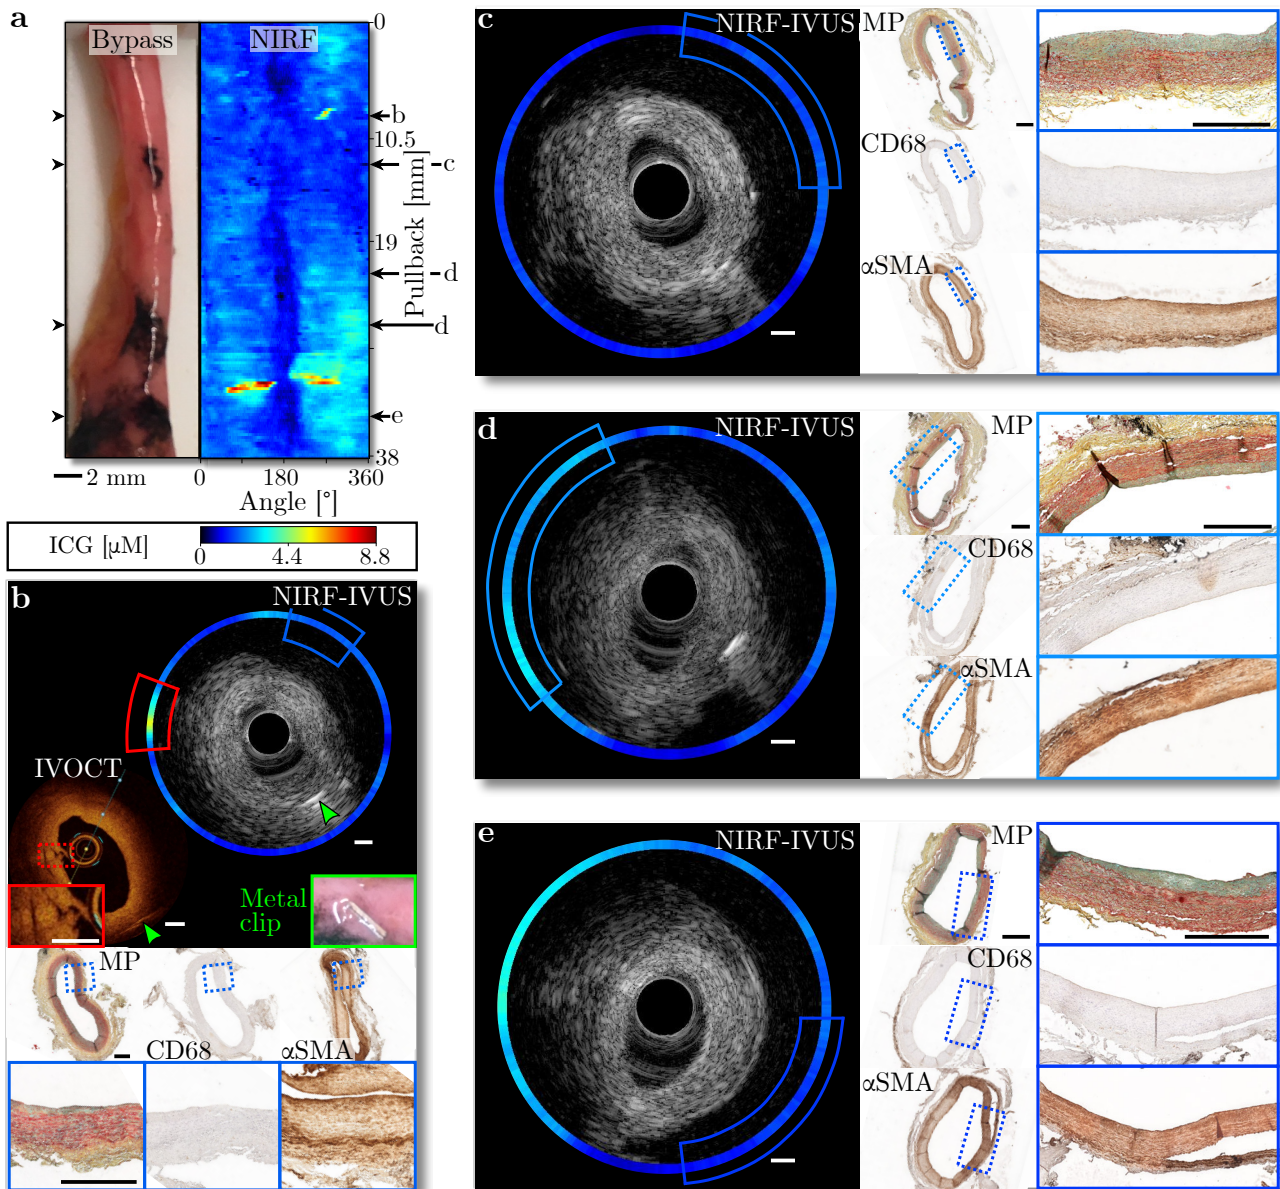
Intravascular NIRF-IVUS imaging of an ICG-perfused coronary bypass detects low ICG concentrations in healthy tissue regions. a - Picture and corresponding NIRF map of an ICG-perfused bypass; b - Low ICG concentration detected with NIRF-IVUS (Blue box) in healthy tissue regions (MP – Blue box) without the presence of macrophages (CD68, α SMA – Blue box). Increased ICG concentration (Red box) detected with NIRF-IVUS (Red box) in a tissue area showing signs of endothelial damage visible in co-registered (Metal clip as additional angular marker – Green arrow) IVOCT (Red box); c-e - Low ICG concentration detected with NIRF-IVUS (Blue box) in healthy tissue regions (MP – Blue box) without the presence of macrophages (CD68, α SMA – Blue box). In all panels: NIRF: Near-infrared Fluorescence; IVUS: Intravascular Ultrasound; IVOCT: Intravascular OCT; MP: Movat Pentachrome; α SMA: alpha-smooth muscle actin; ICG: Indocyanine Green; Scale bars: 500 μ m.
